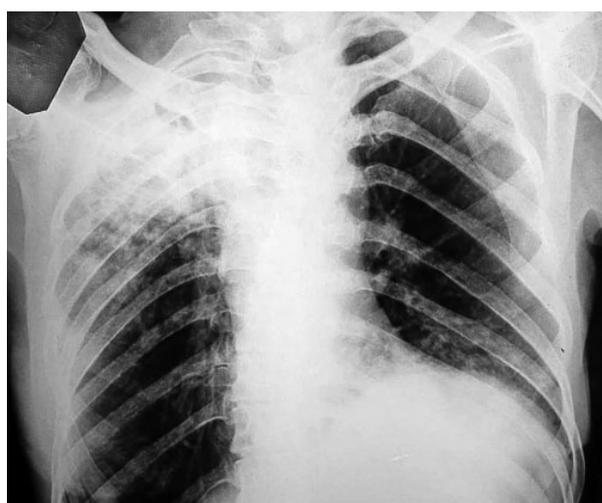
A 51-year-old woman; chest X-ray after anti-pneumonic treatment shows no change
